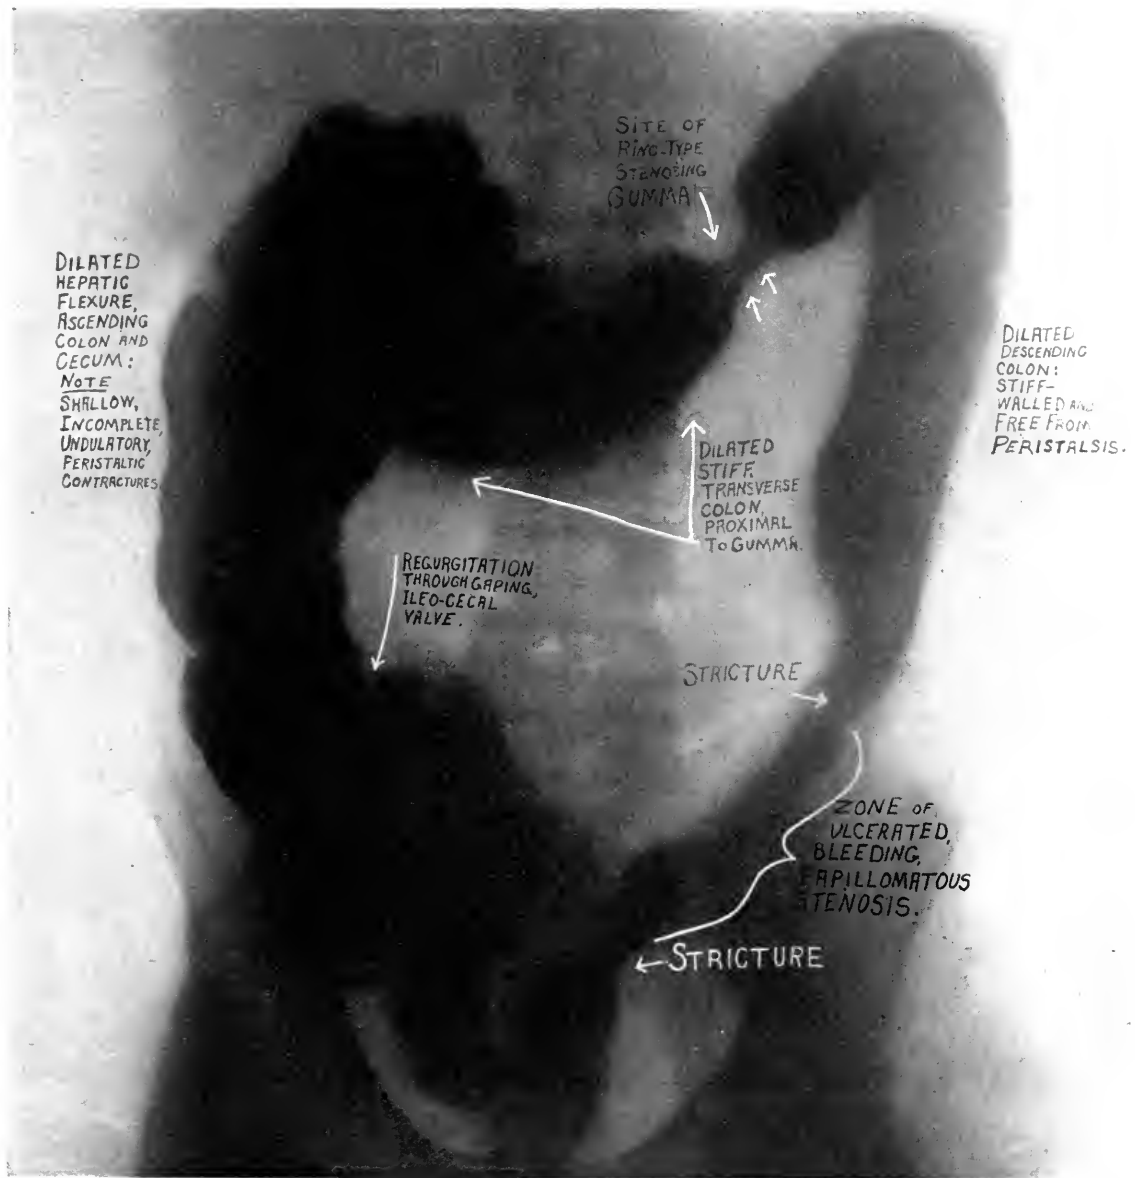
Case 1. Roentgenogram showing luetic lesions of the colon before specific therapy had been instituted. (Joseph Johnston, roengenographer).
